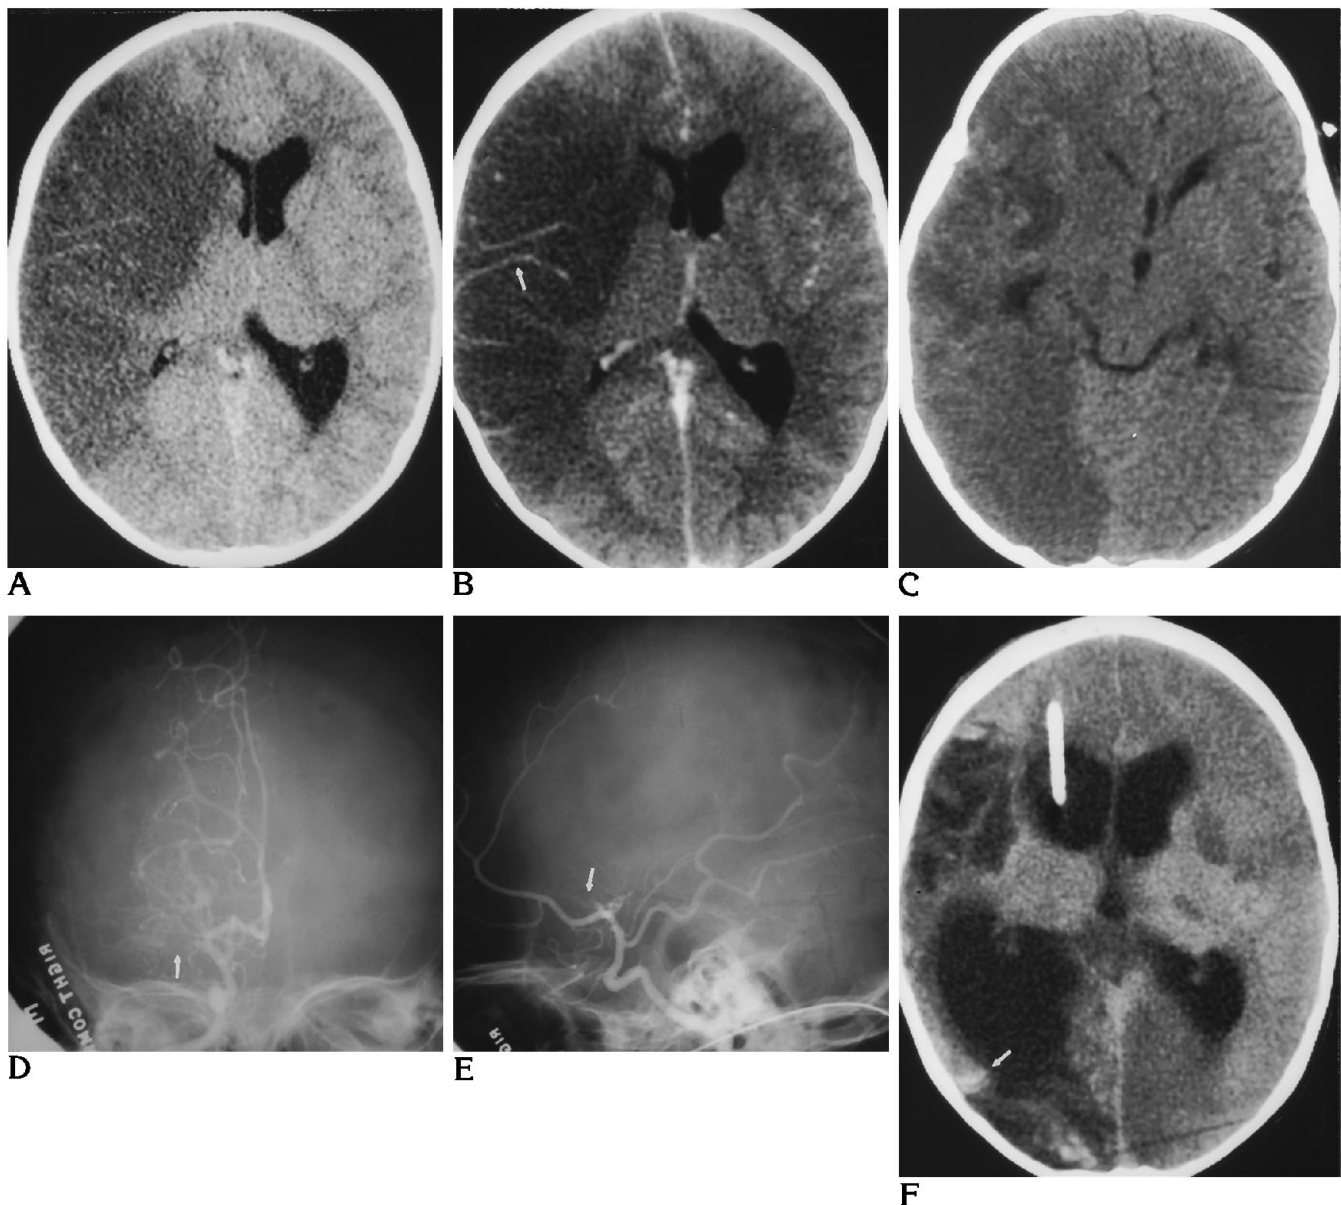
A, Noncontrast and B, contrast-enhanced CT images demonstrate low attenuation in the distribution of the right middle cerebral artery with mass effect (midline shift), trapping of the left lateral vehicle, and mild vascular enhancement (arrow in B).
